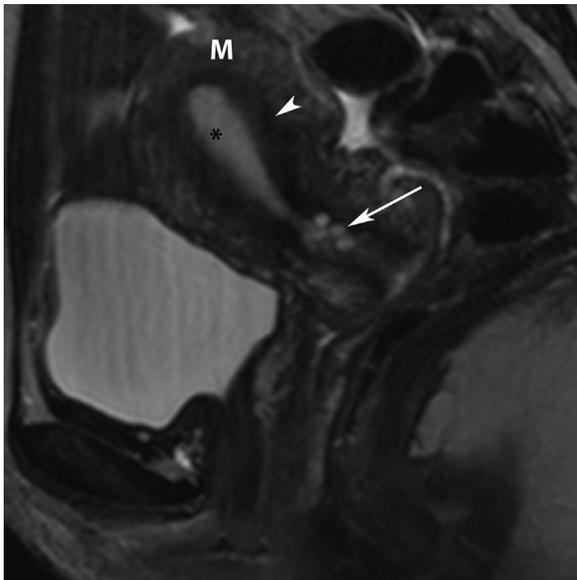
A 30-year-old premenopausal woman with breast cancer who had MRI to evaluate ovarian cysts. Sagittal T2 MRI demonstrates normal appearance of the uterus. The endometrium is T2 hyperintense (asterisk). It is surrounded by a low T2 signal intensity junctional zone that measures 8 mm or less (arrowhead). The surrounding myometrium is higher signal intensity than the junctional zone (M). Incidental note is made of nabothian cysts at the cervix (arrow).
